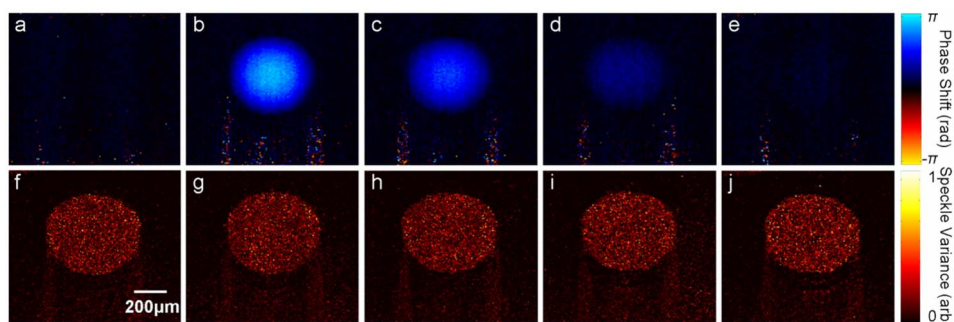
(Color online) a, Doppler phase shift measured for stationary Intralipid within a  $600 \mu\text{m}$  tube at an  $80^\circ$  Doppler angle. b–e, Doppler phase shift measured from Intralipid moving through the tube at a rate of 12 ml/h for Doppler angles of  $75^\circ$ ,  $80^\circ$ ,  $85^\circ$ ,  $89.5^\circ$ , respectively. f–j, Corresponding normalized (to fixed value for all images) speckle variance images.
